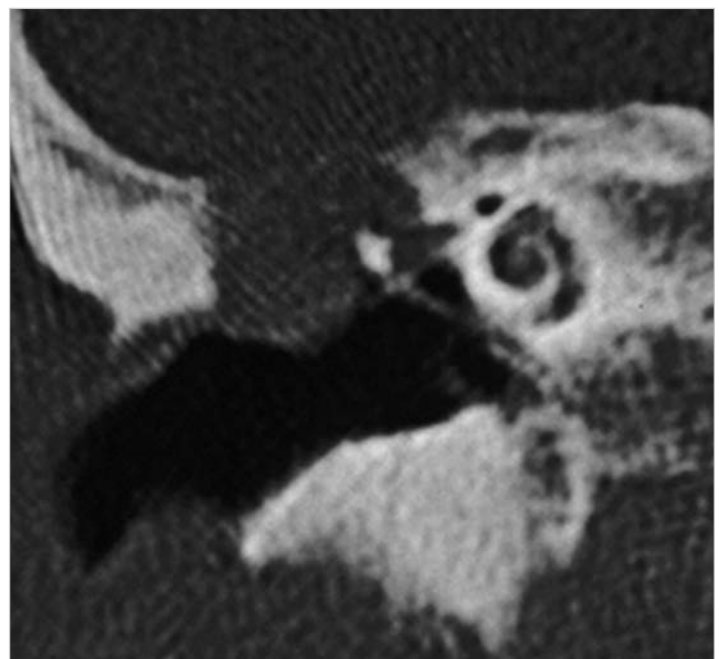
CT scan, coronal view, of the same case. Large bony defect of the tegmen tympani with soft tissue protruding into the middle ear.
